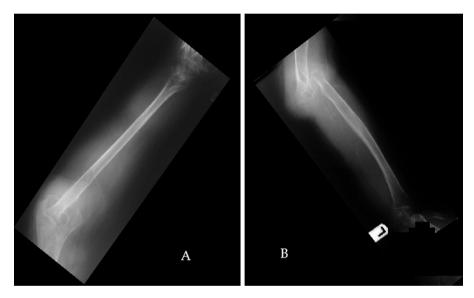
(A) Lateral and (B) AP radiographs of the forearm demonstrating advancement of the lytic lesion despite radiation treatment resulting in dislocation of the radial – humeral articulation and significant pain with loss of function.
